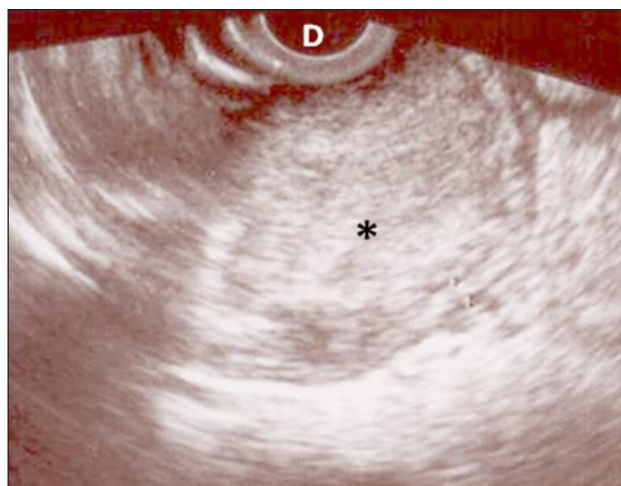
Endosonographic image of the gastrinoma seen as 28 by 30 mm size tumor of irregular echogeneity (asterisk), located within the submucosal layer of the duodenal bulb (D)
